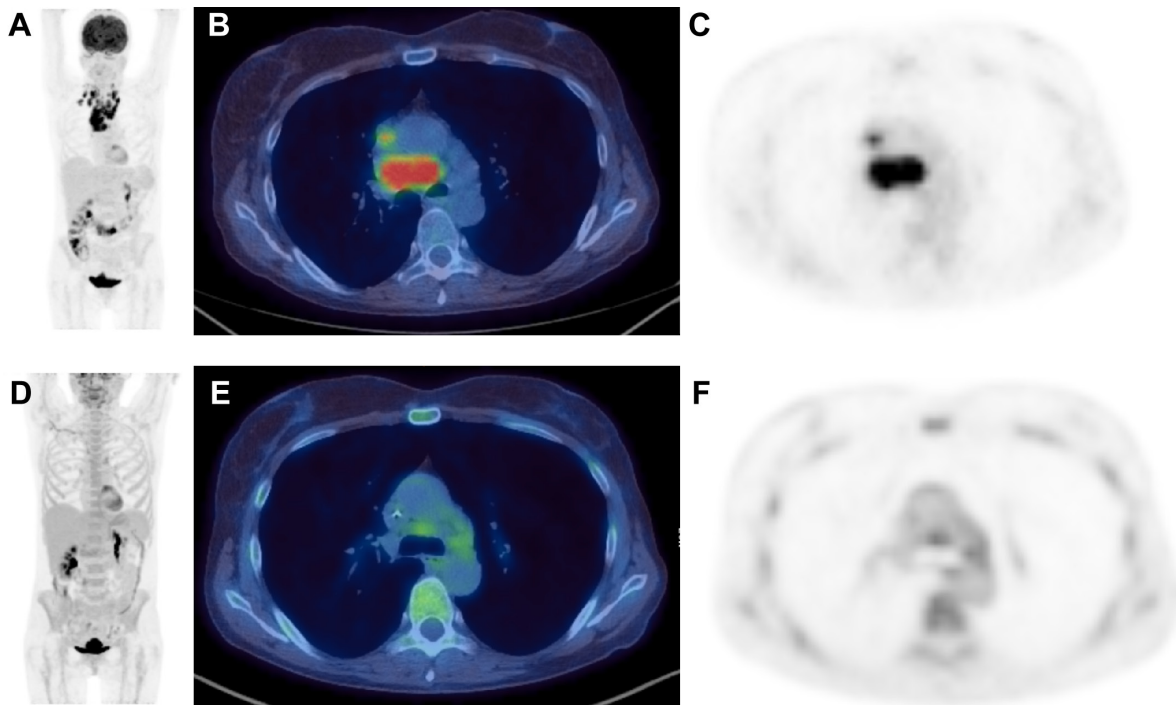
Baseline and post-treatment PET-CT in a patient with Hodgkin lymphoma. PET demonstrated very good partial metabolic response with residual low-grade uptake in mediastinal nodes. The intensity of uptake was slightly greater than liver background, classified as Deauville score 3. The patient was asymptomatic and therefore serial PET imaging was used to monitor the equivocal uptake, which resolved despite the absence of anti-lymphoma treatment. The residual low-grade uptake therefore most likely represents post-treatment inflammatory changes. (A) Baseline MIP shows intense uptake in cervical and mediastinal nodes. (B) Transverse fused image shows intense uptake in enlarged pretracheal nodes. (C) Transverse PET only image shows intense uptake in enlarged pretracheal nodes. (D) Post-treatment MIP shows resolution of the areas of intense uptake. (E) Transverse fused image shows residual lowgrade uptake in pretracheal nodes. (F) Transverse PET only image shows residual lowgrade uptake in pretracheal nodes.
